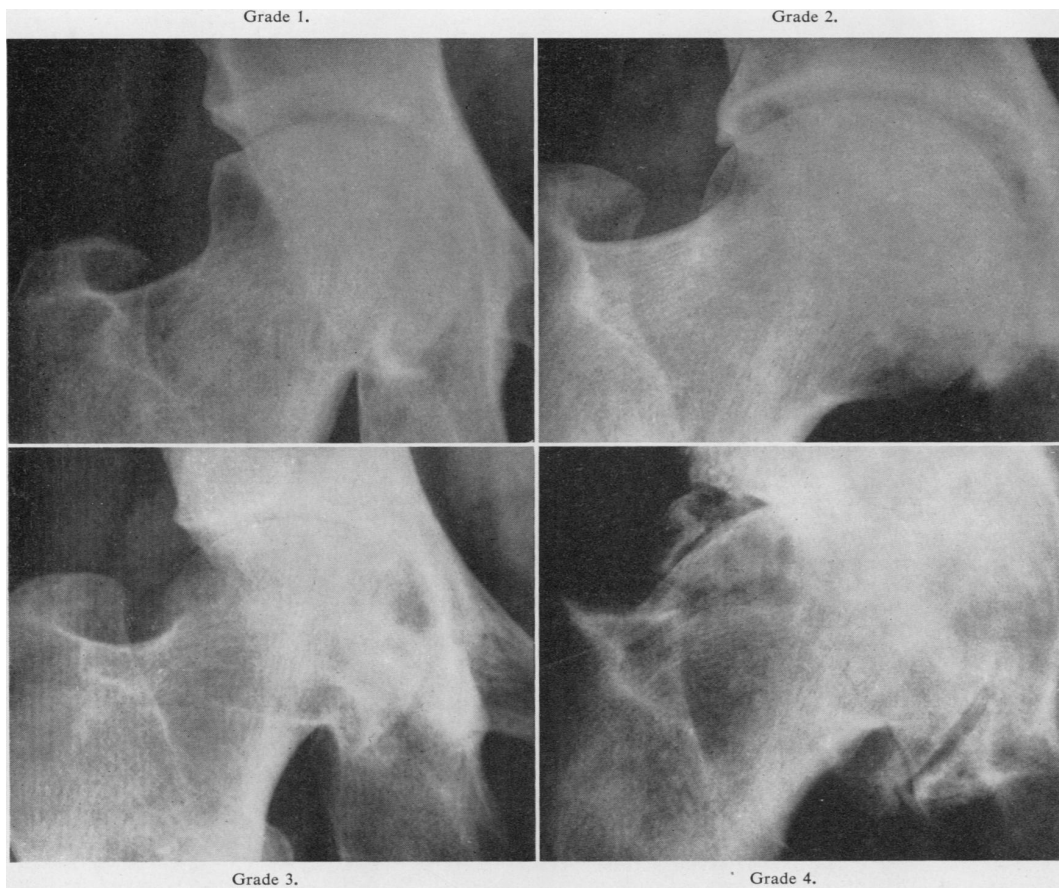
Kellgren & Lawrence Hip Osteoarthritis Reference Grading Radiographs [19].
